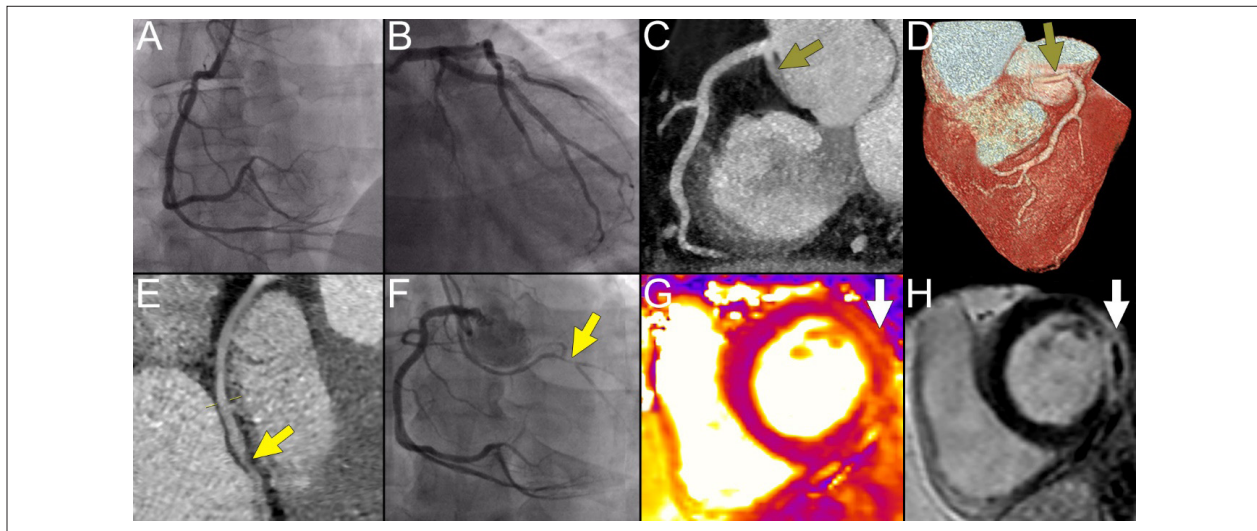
Coronary angiography, coronary computed tomography angiography and cardiac magnetic resonance findings of the patient with challenging diagnosis of myocardial infarction and anomalous left circumflex artery.
